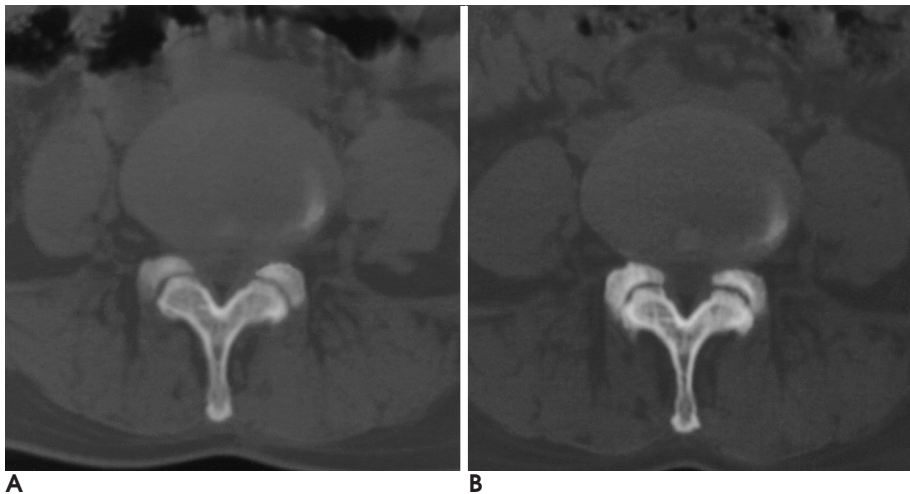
A 38-year-old female patient with right central disc protrusion at the L4-5 disc level, and this patient underwent PELD two months after the initial surgery. A, axial CT scan images of the facet joint obtained before surgery. The CT scan taken 38 months postoperatively shows the facet joint has changed from grade II (A) to III (B).
